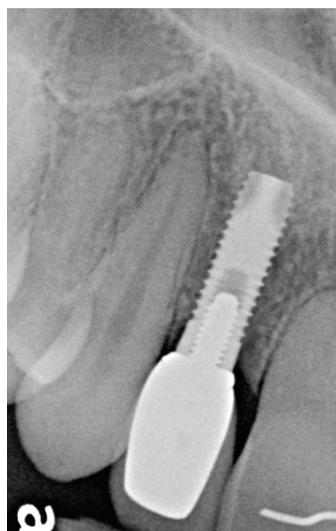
Implant radiograph at recall appointment shows stable bone levels and a secure restoration.
